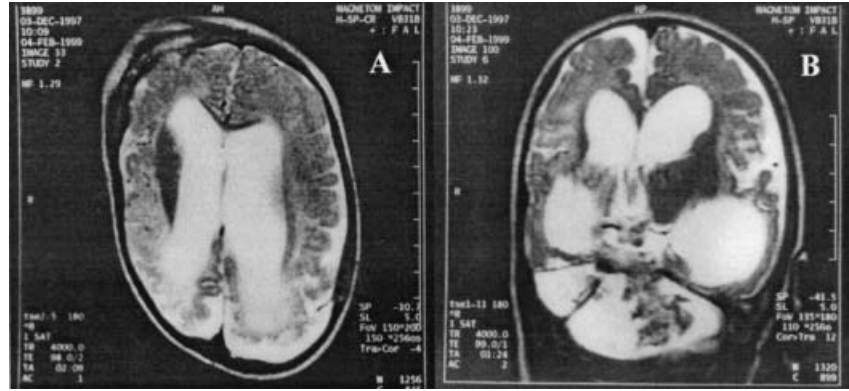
Example of “moderate” degree of involvement in cranial magnetic resonance imaging (3-year-old boy with hypoxic–ischemic encephalopathy): Bioccipital subcortical gliotic lesions, prominent in T₂-weighted image. A: T₁-weighted image. B: T₂-weighted image.
